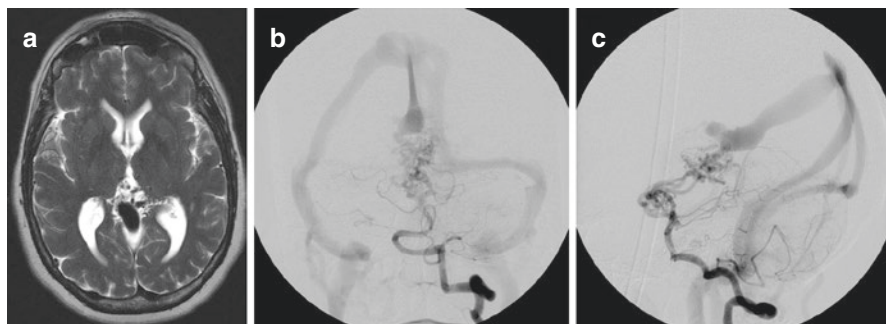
(a) Axial T2-weighted magnetic resonance image showing an enlarged venous structure within the velum interpositum posterior to the third ventricle in approximation to numerous arterial structures. (b) Frontal and (c) lateral left vertebral artery cerebral angiograms demonstrating the Lasjaunias choroidal type vein of Galen aneurysmal malformation, with arterial supply from enlarged bilateral posteromedial and posterolateral choroidal arteries, venous drainage into the median prosencephalic vein of Markowski, and a persistent falcine sinus
